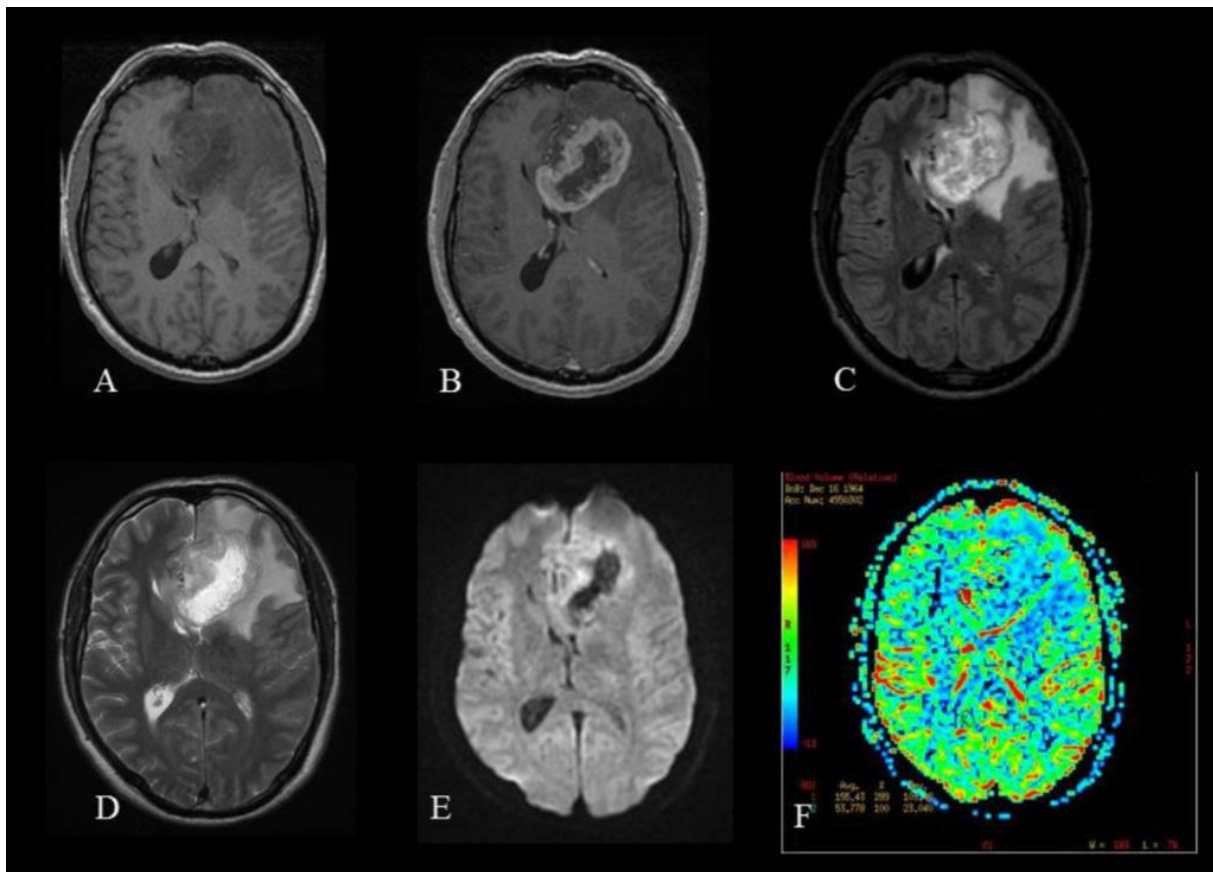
Multimodal brain MRI using T1-weighted (A), T1-weighted with injection of contrast agent (B), FLAIR (C), T2-weighted (D), diffusion (E) and perfusion (F) sequences (adapted from [28]).
